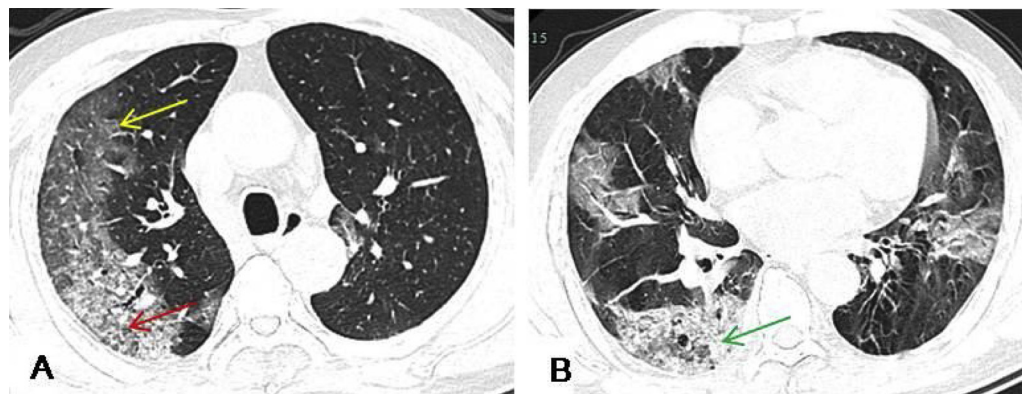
A 73-year-old male presented with a 2-week history of dry cough and a 1-week history of fever. HRCT revealed multiple patchy and large patchy GGO (yellow arrow) with crazy paving pattern (red arrow) under the pleura in both lungs, and mixed with consolidation of the right lower lobe lesions (green arrow). Most lesions were located in the peripheral zone of both lungs.
